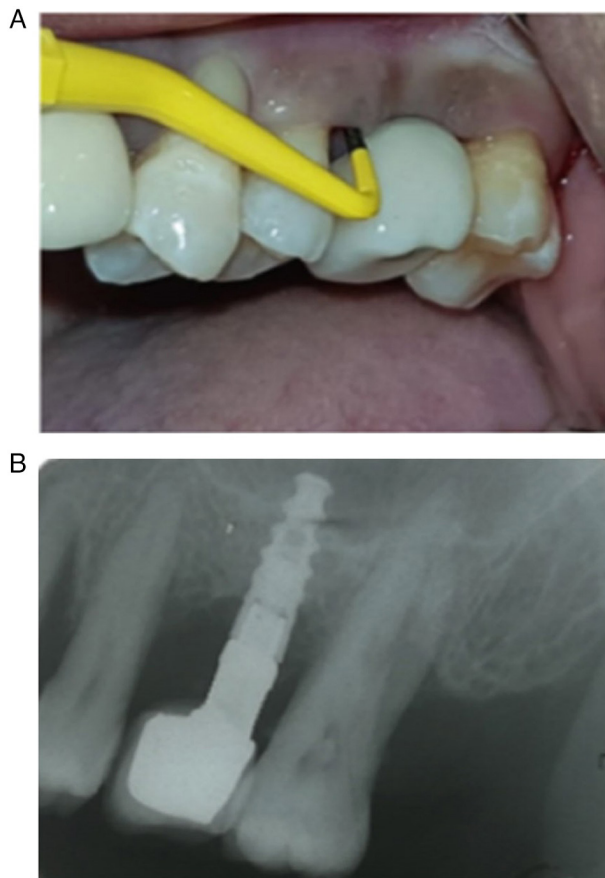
Clinical and radiological assessment of a patient with peri-implantitis. (A) Periodontal pocket depth >5 mm. (B) Radiographic bone loss >2 mm.
